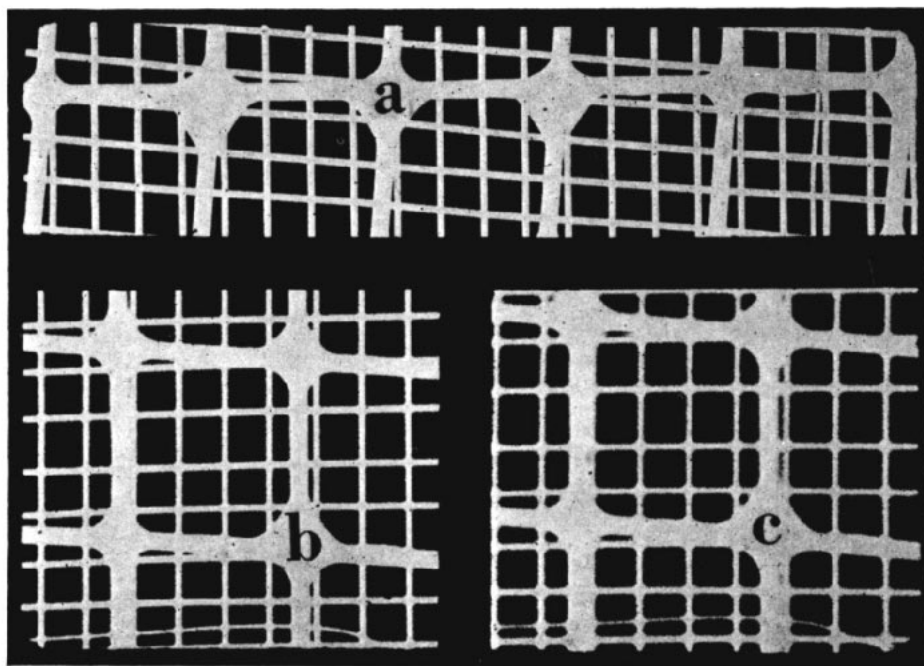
The effect of X-ray target size. The subject is wire mesh; large squares are  $1/4''$  mesh, small squares  $1/16''$  mesh. Target 1.5 mm. Target-subject distance 5 feet.
